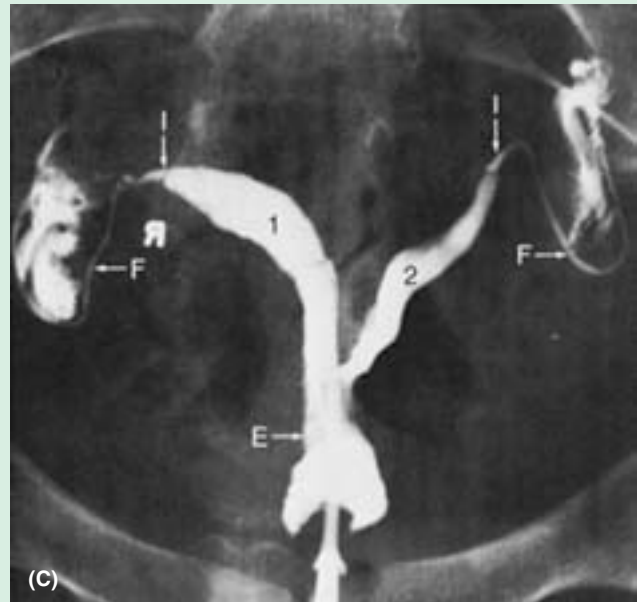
Radiograph of uterus and uterine tubes (hysterosalpingogram). A. Radiopaque material was injected into the uterus through the external os of the uterus. The contrast medium traveled through the triangular uterine cavity and uterine tubes (*arrowheads*) and passed into the pararectal fossae of the peritoneal cavity (lateral to the *arrowheads*). The female genital tract is in direct communication with the peritoneal cavity and is, therefore, a potential pathway for the spread of an infection from the vagina and uterus. *c*, catheter in the cervical canal, *vs*, vaginal speculum. B. For this iliac arteriogram, radiopaque dye has been injected into the aorta in the lumbar region. Features demonstrated include bifurcation of the aorta into right and left common iliac arteries (anterior to L4), bifurcation of the common iliacs into internal and external iliac arteries (opposite the sacroiliac joint at the level of the lumbosacral disc), and a site of narrowing (stenosis) of the right common iliac artery (*circled area* on the arteriogram). (Courtesy of Dr. D. Sniderman, Associate Professor of Medical Imaging, University of Toronto, Toronto, ON, Canada.) C. This hysterosalpingogram shows a bicornate uterus. *1* and *2*, uterine cavity; *E*, cervical canal; *F*, uterine tube; *I*, isthmus of tube. (Reprinted with permission from Stuart GCE, Reid DF: Diagnostic studies. In Copeland LJ (ed): *Textbook of Gynecology*. Philadelphia, Saunders, 1993.)
